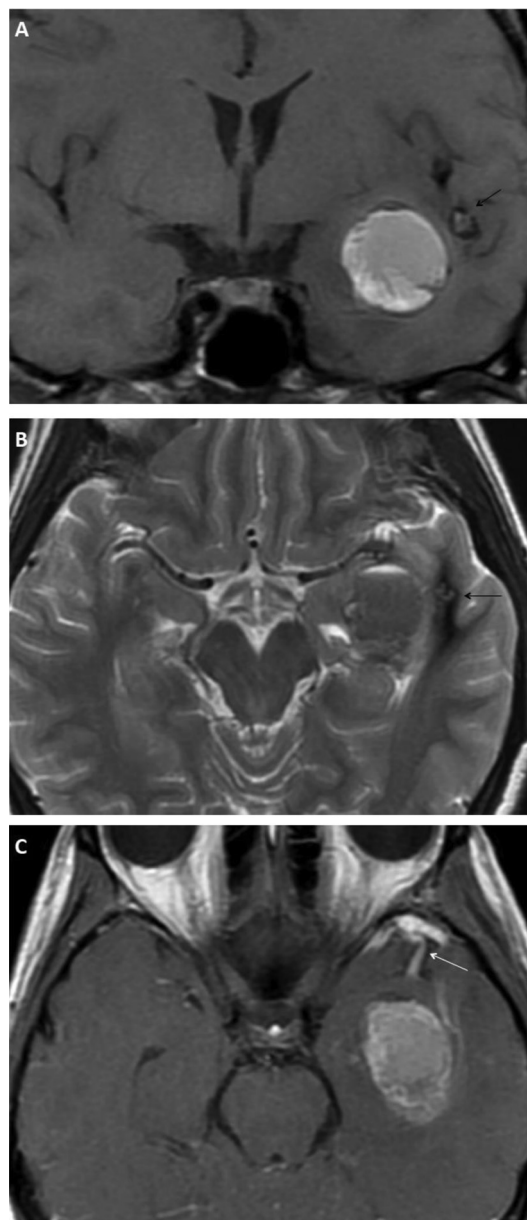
(A) Coronal T1-weighted image (T1WI); (B) axial T2WI revealing a hematoma of 3 cm × 2.5 cm. A suspected cavernous hemangioma adjacent to the hematoma noted with mixed bright and dark signal intensities on both T1WI and T2WI (black arrow); (C) contrast-enhanced T1WI revealing a concomitant developmental venous anomaly with a tube-like enhancement of an engorged vein in front of the hematoma in the anterior temporal region (white arrow).
